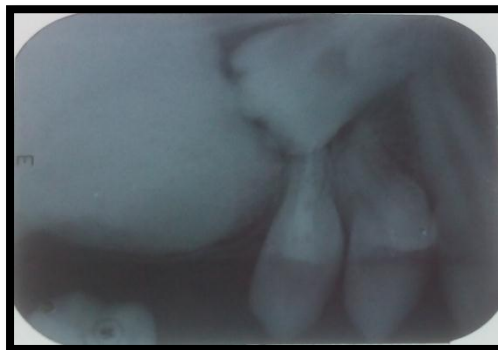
Intraoral periapical radiograph showing 25 after endodontic treatment.
